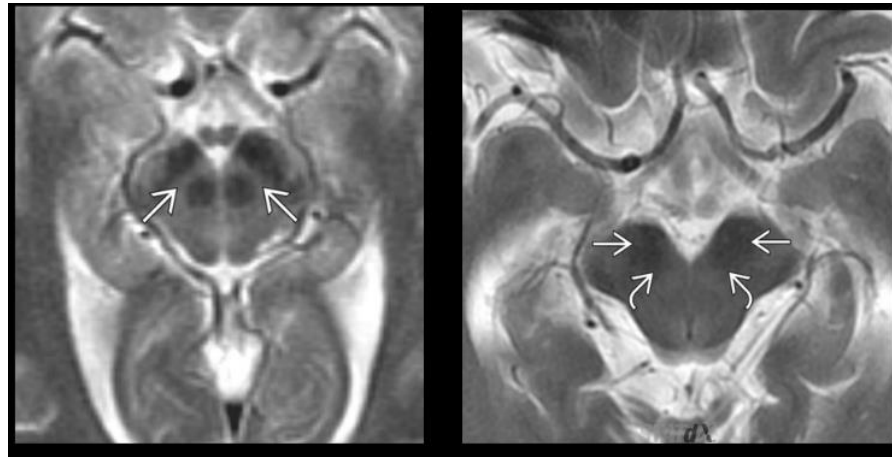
Axial T2 MR images compare normal midbrain with Parkinson's disease midbrain. The second image shows blurring and thinning of pars compacta. Subsequently, the red nuclei and substantia nigra are almost touching.³⁴
